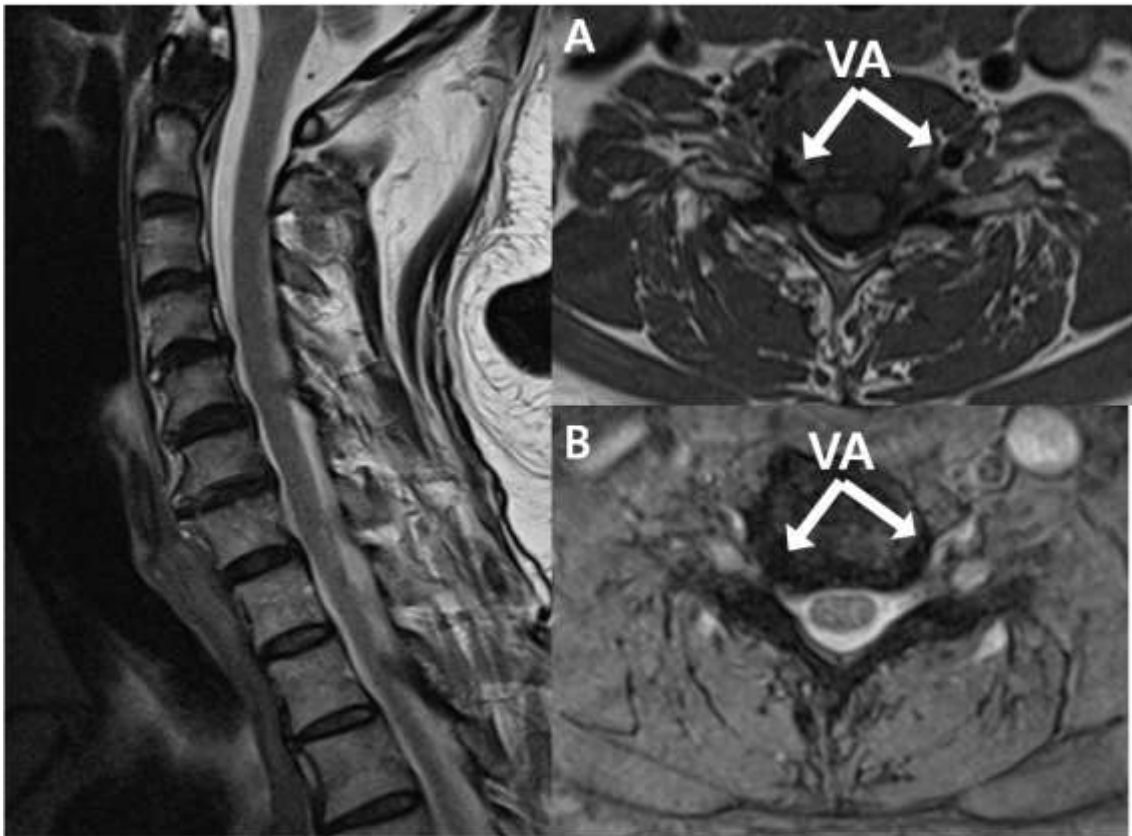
On the T2WI (A) and T2 contrast-enhanced (B) cervical MRI, left vertebral artery (VA) that were torsioned relative to the opposite side, reaching the left C7 nerve root.
